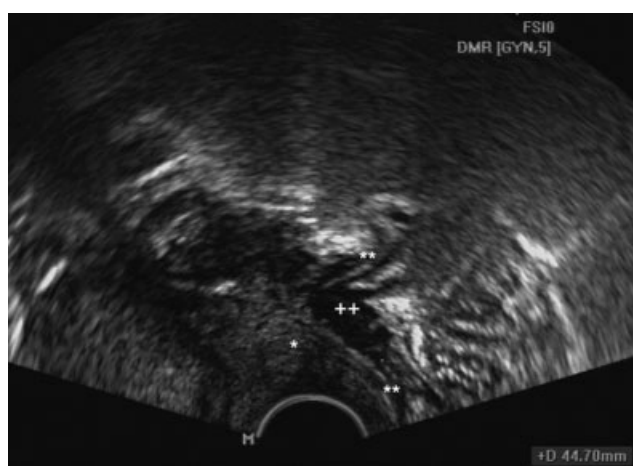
Transvaginal sonography demonstrating a solid hypoechogenic nodule (++) behind the cervix (*) situated within the anterior rectosigmoidal wall (), corresponding to deep infiltrating endometriosis of the rectosigmoid with a hyperechogenic rim reflecting the rectosigmoidal submucosa. The hypoechogenic area represents infiltration and hypertrophy of the rectosigmoidal muscle.
